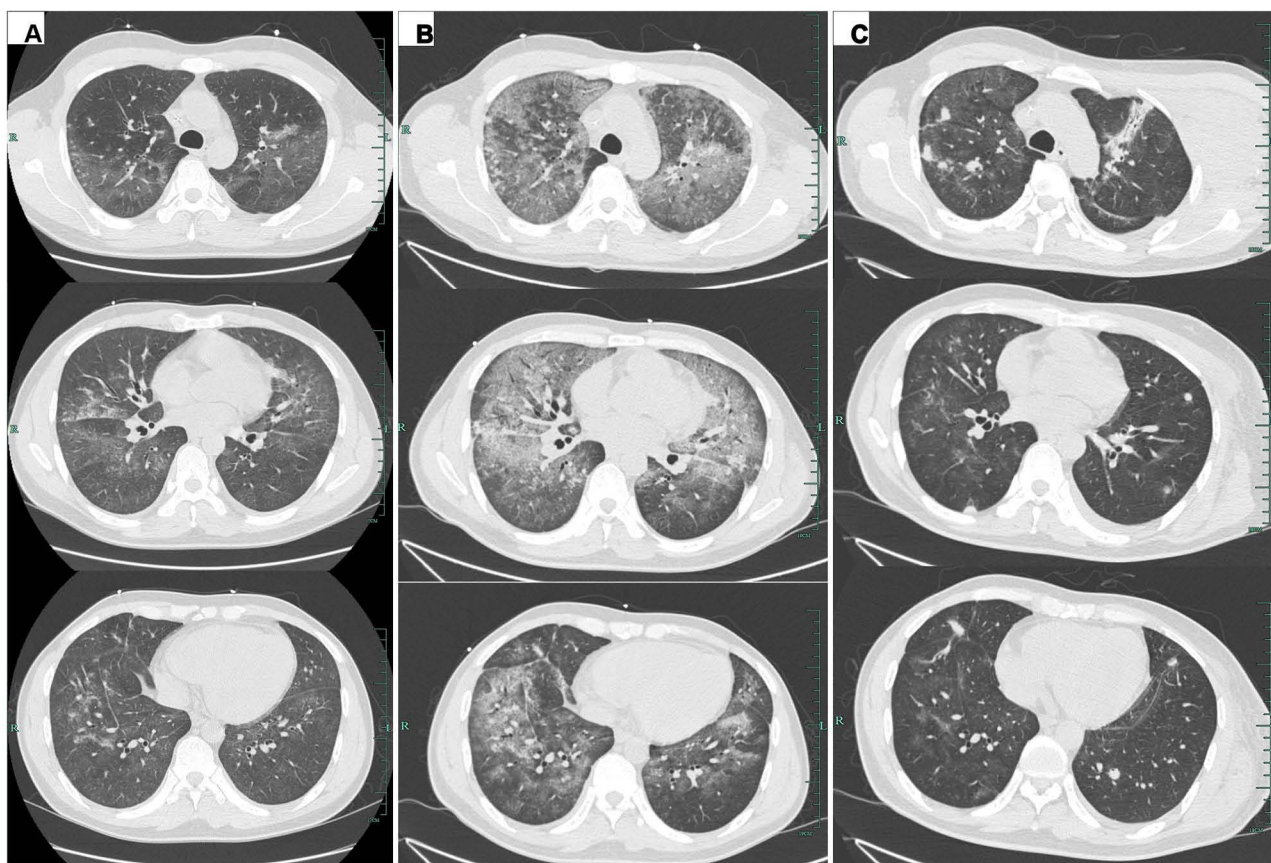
Serial chest CT scans at D1, D10, and D30 during the anti-infection period: (A) the initial CT scan at D1 showed an increased texture of both lungs increased, with multiple slight exudations and a small pleural effusion; (B) CT scan on D10 after admission revealed multiple progressive patchy shadows on both lungs, with ground-glass opacities and inflammatory exudates; (C) the follow-up CT scan on D30 after admission showed resolution of the bilateral diffuse patchy shadows, and increased multiple nodules increased in both lungs, with no pleural effusion. CT, computed tomography.
